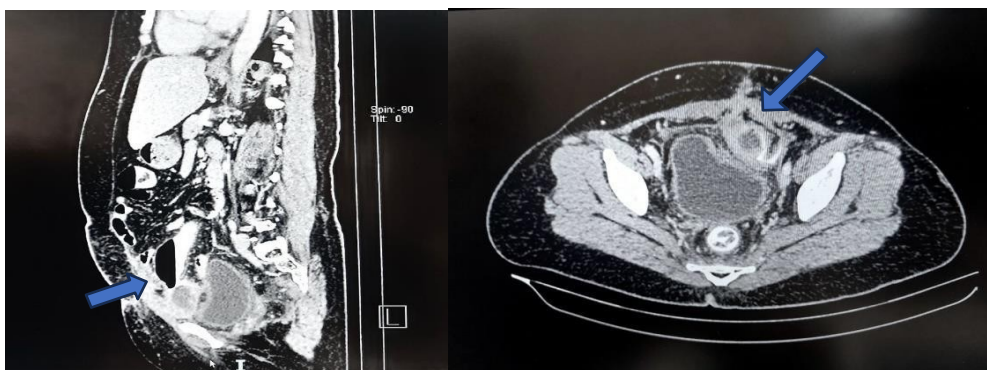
CT was also done confirming the recurrence of the tumor invading the sigmoid colon, left rectus muscle and urinary bladder
